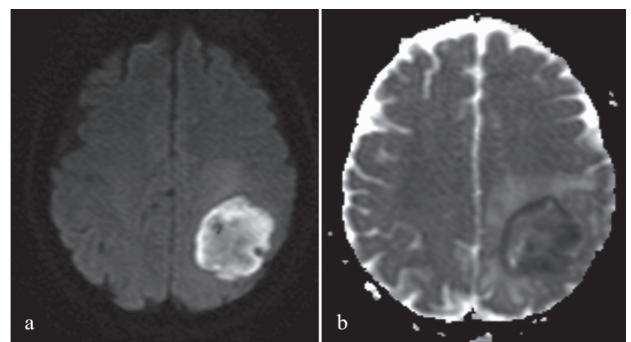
DWI image (a) and ADC map (b)
